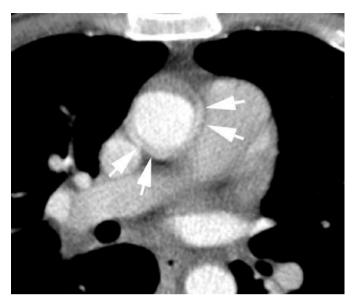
Ungated CT angiogram of the aorta demonstrating pulsation artefact (arrows).
